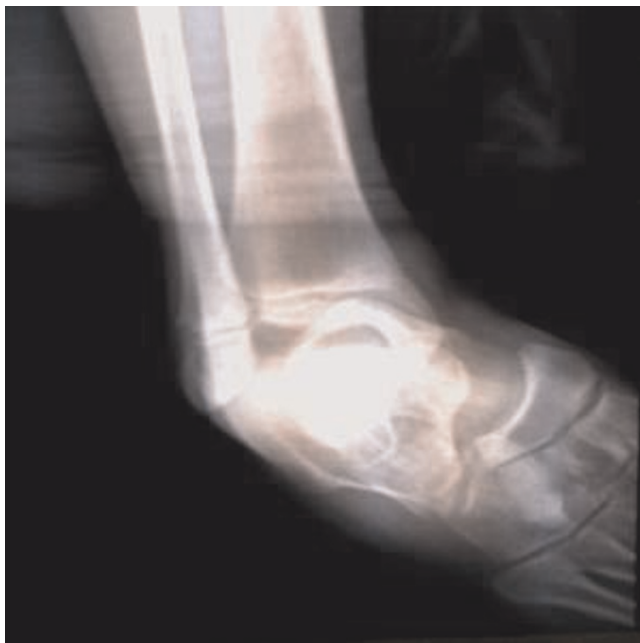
AP X-ray graphy of the ankle representing medial dislocation.
